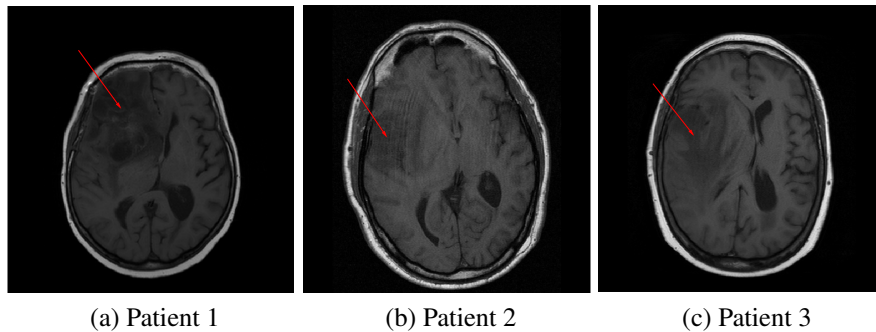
Mass-effect from three different patient cases. The slices were taken from a T1-weighted MRI. The tumors are located in areas pointed out by the arrows. The images were provided by The Brain Tumor Analysis Project at University of Alberta [67].
